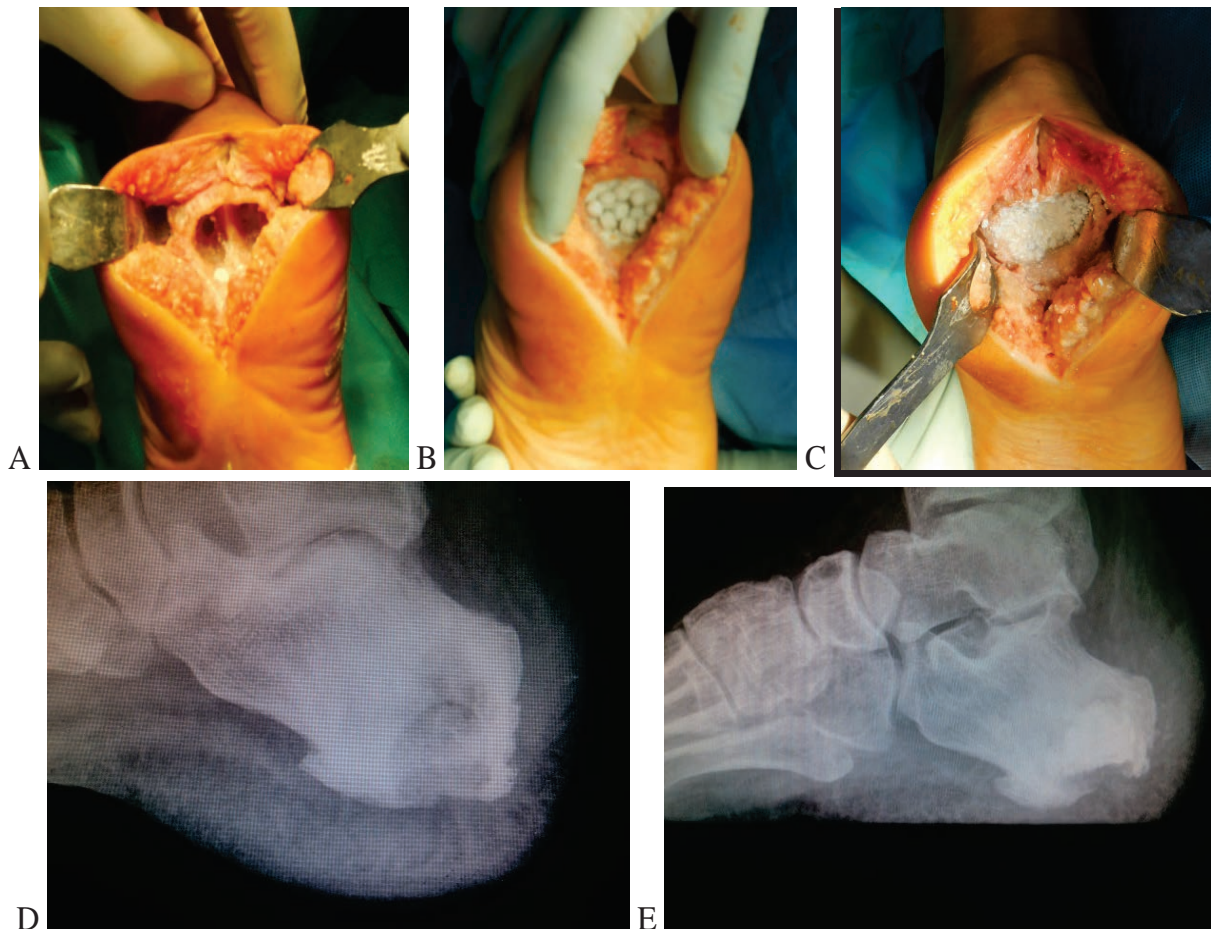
A-C: filling of cavitory bone defect with Herafil pellets after debridement of infectious focus in calcaneus; preoperative (D) and postoperative radiographs (E).
